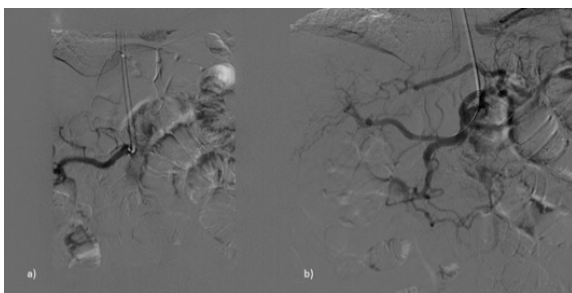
Angiography: CT stent placement.
